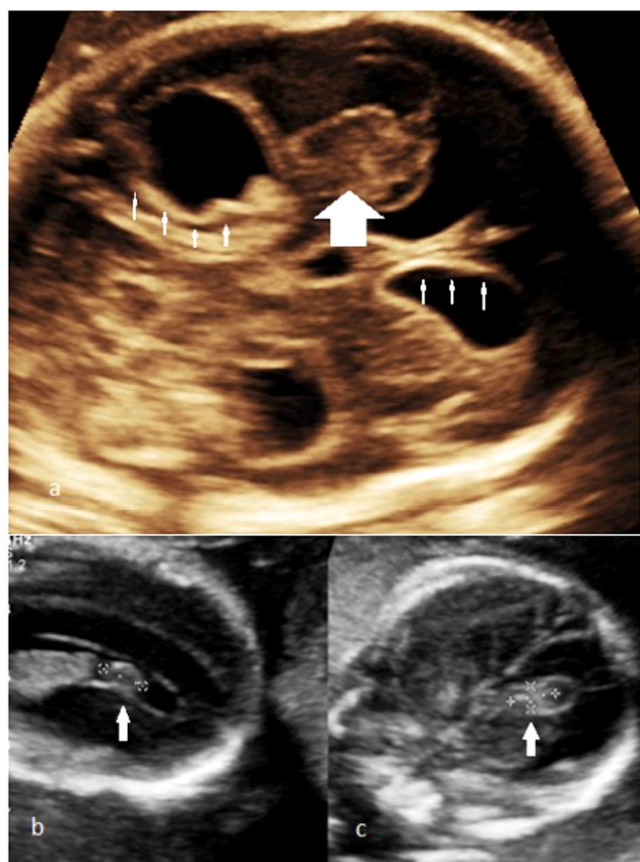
Ultrasound findings in fetal IVH: a) large avascular, echogenic mass in a porencephalic cavity (large arrow) associated with ventriculomegaly and nodular echogenic ependyma (arrowhead); b) A 20 weeks fetus with unilateral IVH grade 1 (arrows) in parasagittal and coronal views.
